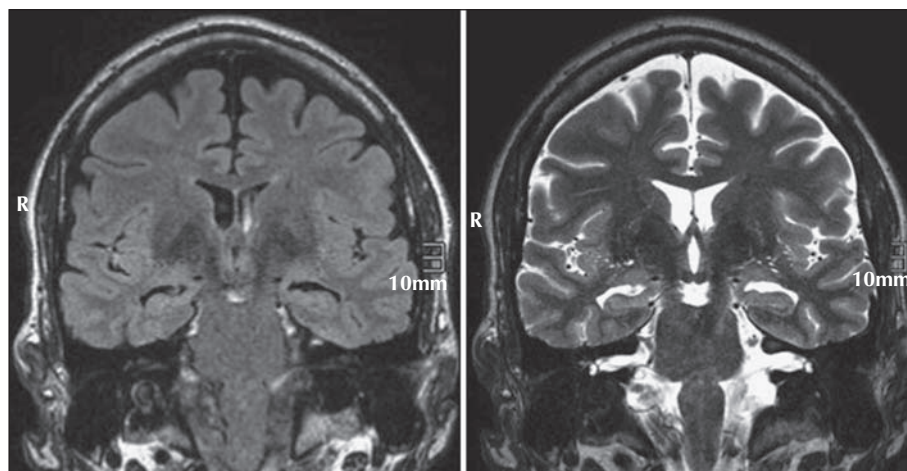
High resolution MRI (3T) shows a blurred internal structure of the right hippocampus without clear atrophy or signal change.
